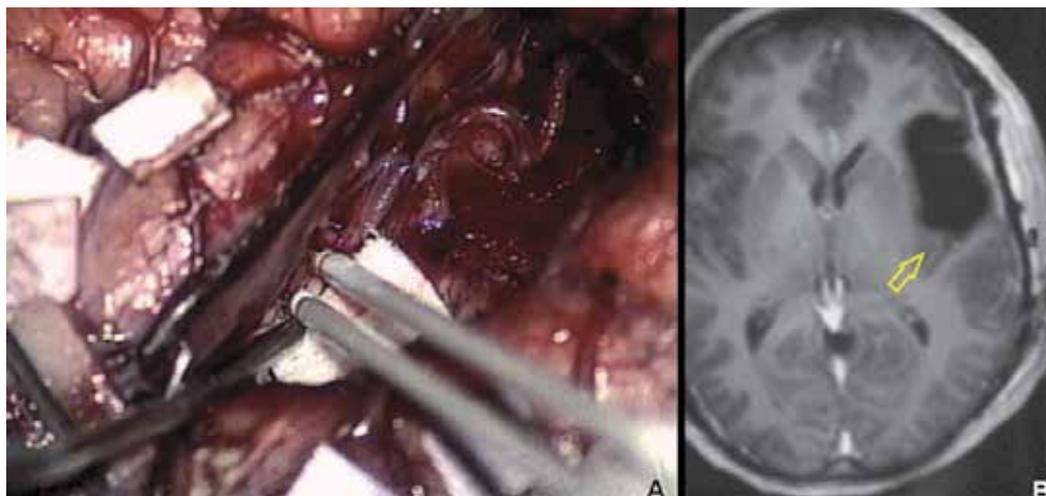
A) The bipolar probe stimulates the cortical surface of posterior insular lobe. In this patient, patient, depicted in previous figures, insular cortical stimulation elicited speech arrest, which put a halt to tumoural resection. B) A postoperative (one month) T1-weighted Gd-enhanced MRI the tumoural residue is clearly seen at the level of the posterior insular lobe, where ESM elicited speech arrest (yellow arrow).
